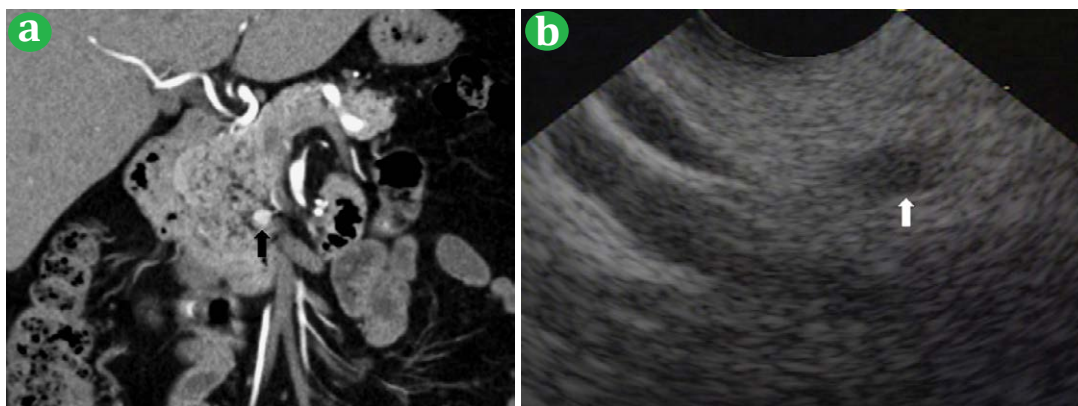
Tumor detected by Endoscopic ultrasound (Non-functioning tumor, G1). (a). Dynamic computed tomography scan shows a slightly hyper-vascular mass. (b). Endoscopic ultrasound shows a small hyperechoic tumor with well circumscribed margins.
